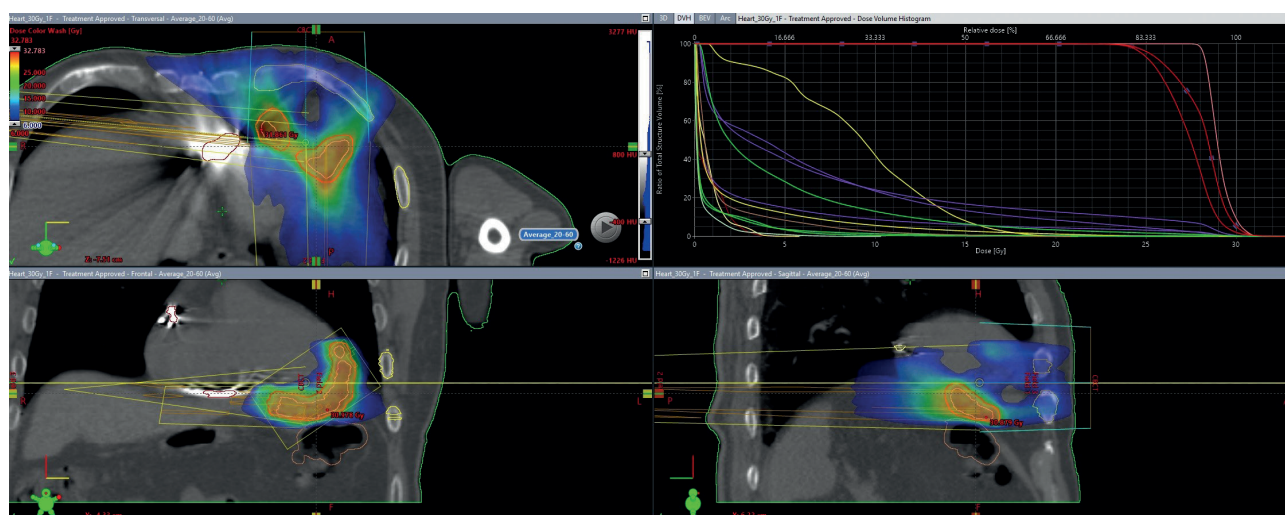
Dose distribution visualisation, projection of the target area in the left ventricle onto native cardiac CT of a patient in the Eclipse treatment planning system.
